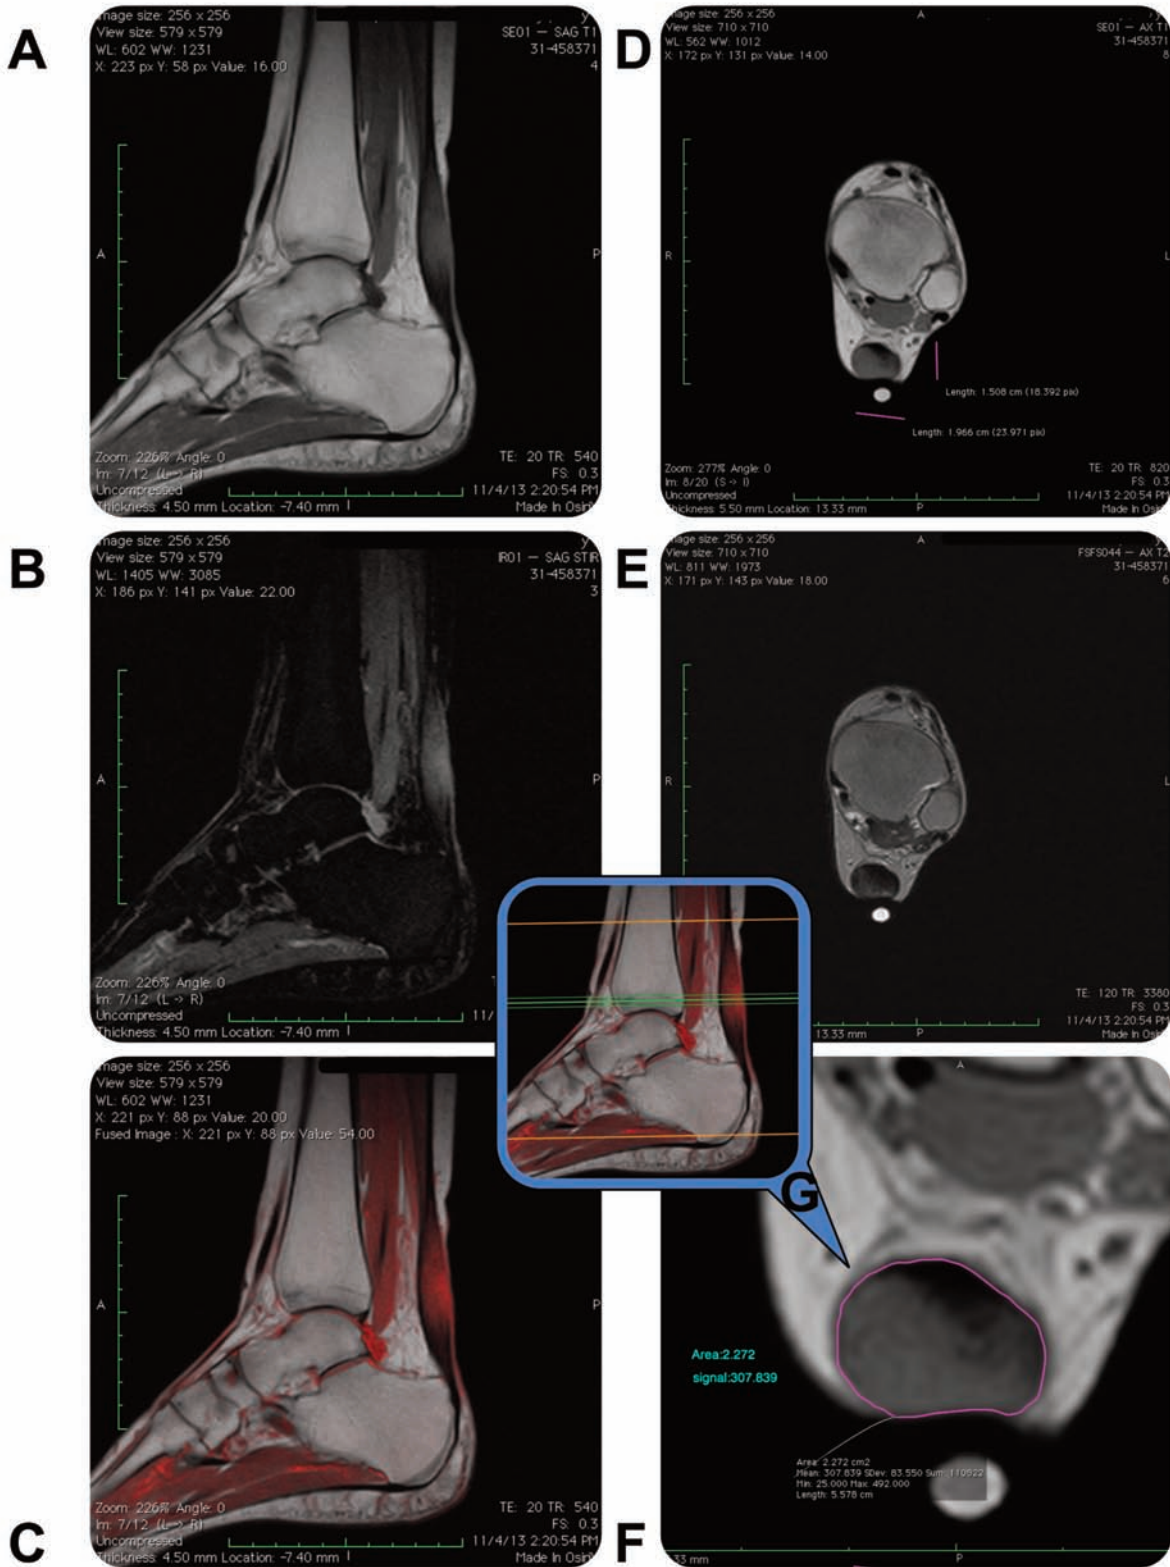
MRI of the patient's left ankle pre-operatively, performed on a Hitachi 0.3 Tesla device. The name of the patient has been blacked out. T1 images used for calculations were both performed with a TE of 20, and a TR of 820, utilizing 5.5 mm slice thicknesses. Color fusion with OsiriX Imaging Software. *A*, Sagittal T1 left ankle. *B*, STIR Sagittal left ankle. *C*, Sagittal T1 fused with a sagittal STIR left ankle. *D*, Axial T1 left ankle. *E*, Axial T2 Fast Spin Echo left ankle. *F*, Axial T1 zoomed to better show the image measurement of signal intensity and area of involved tissue left ankle. *G*, Scout view – center green line represents the image slice in *F* taken at the most involved portion of the tendon left ankle.
